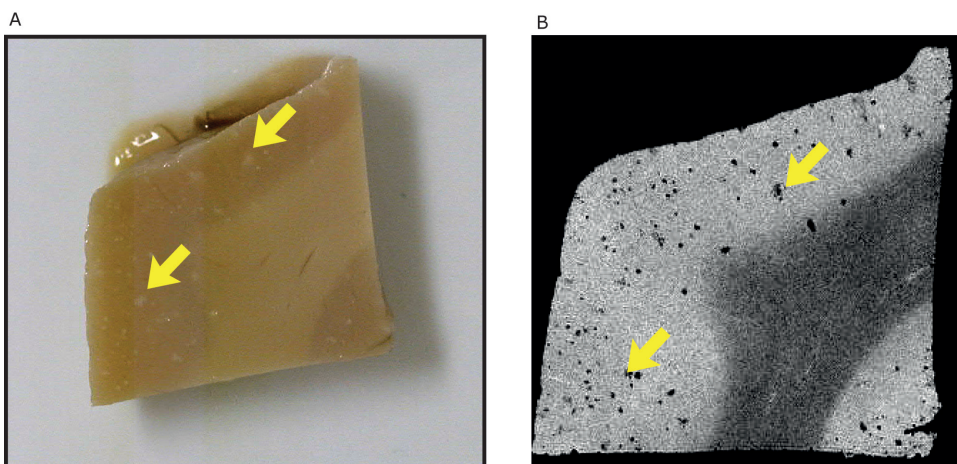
Images from subject 13 showing A) fixated brain tissue with white discolorations (white arrows) and B) high resolution (40 μ m) T2* weighted MR images of the same brain tissue with coarse hypointensities (white arrows).
